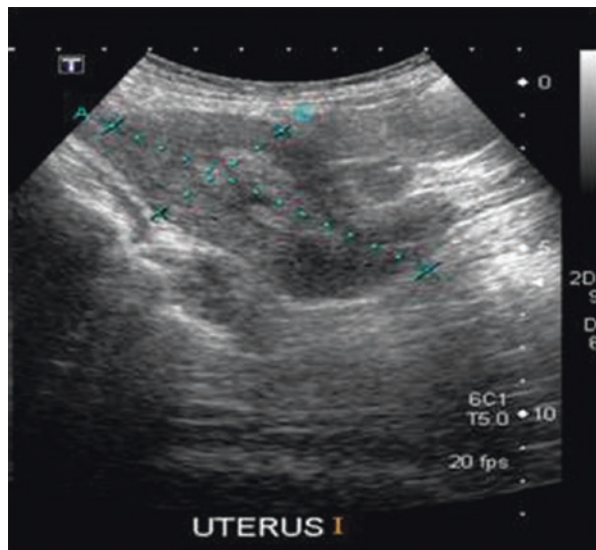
Ultrasonography of a patient with invasive mole showing invasion into the anterior myometrium where there is loss of smooth interface between the echogenic mass and the myometrium
